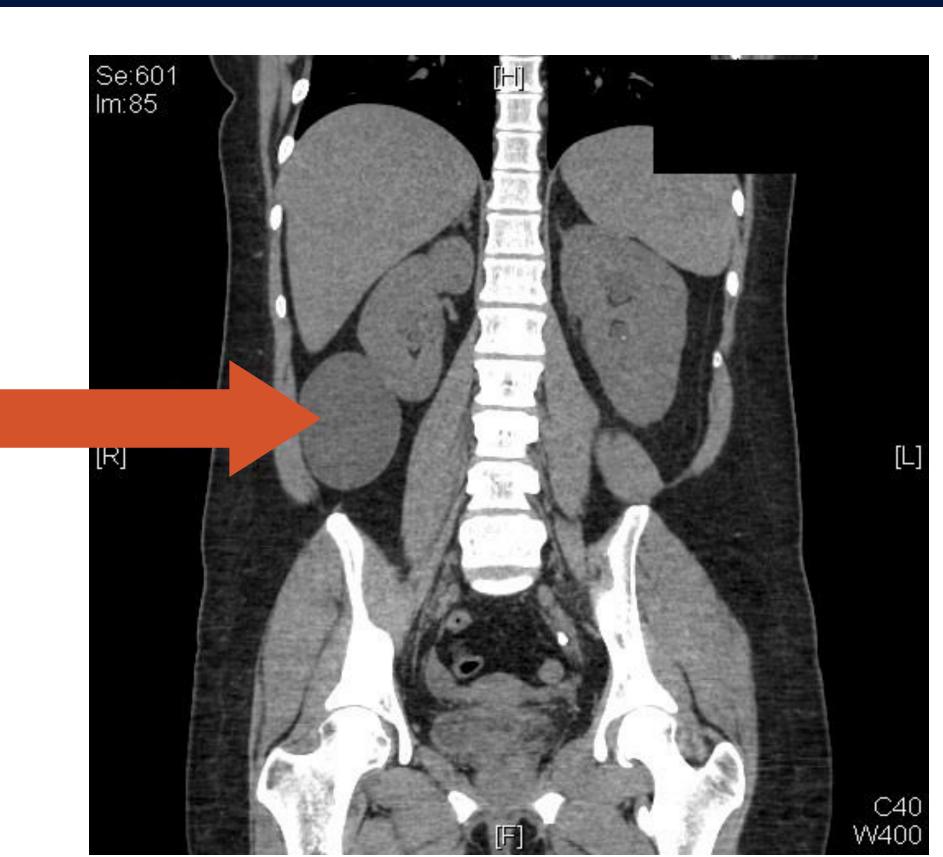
CT scan showing nephrolithiasis and a simple renal cyst measuring 7 cm that is exophytic cyst off her right kidney.
